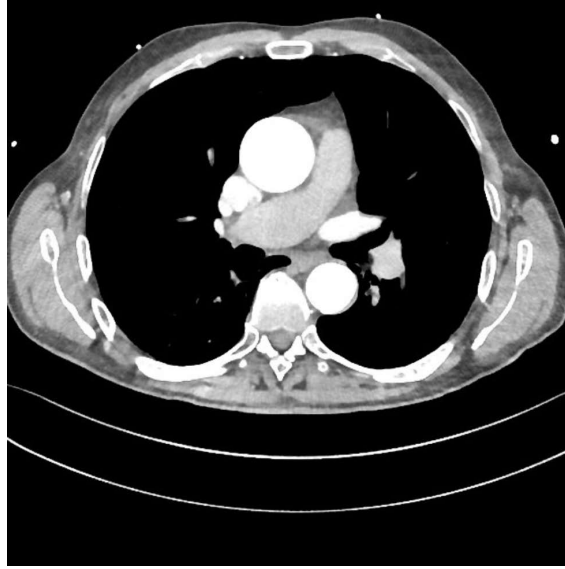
Modern day computed tomographic aortography angiography (CTA) of the aorta, transversal view. This image has been produced after injection of contrast medium to enhance thoracic aorta.
